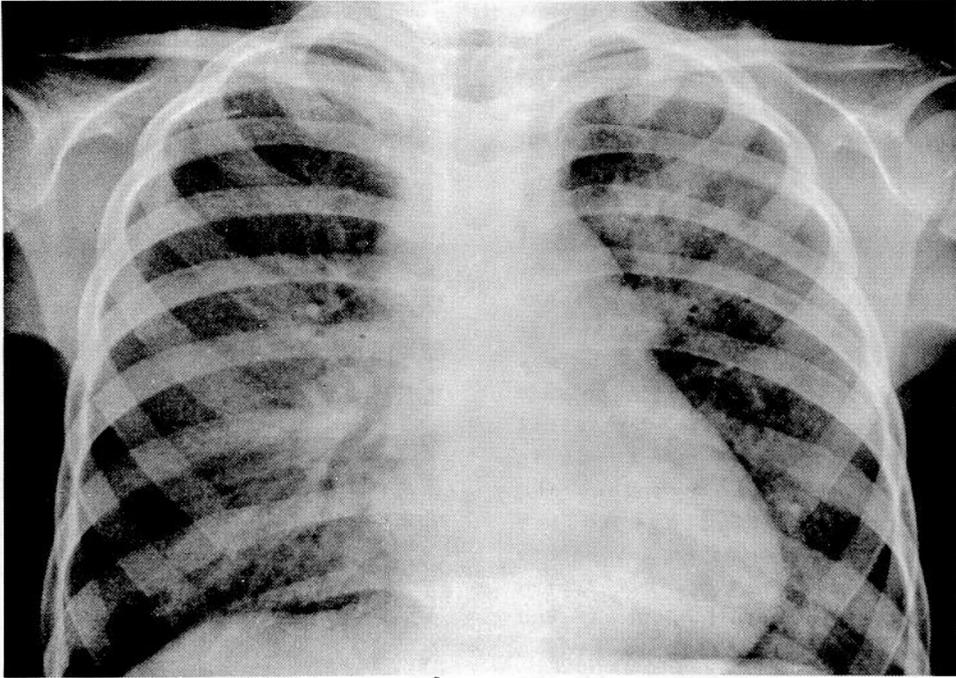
POSTEROANTERIOR CHEST ROENTGENOGRAM OCTOBER 31, 1960 SHOWING INCREASE IN PARENCHYMAL DENSITIES IN LEFT UPPER AND RIGHT LOWER LOBES
